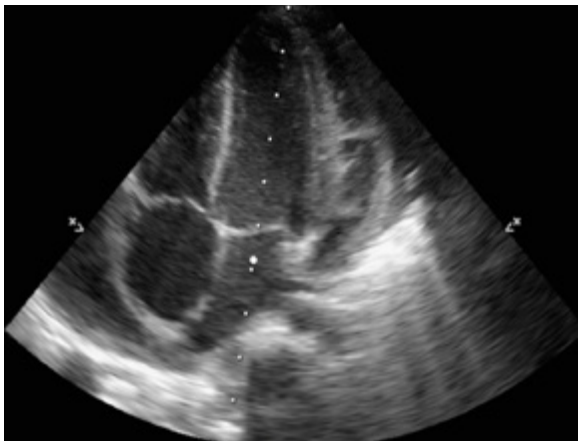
Echocardiogram taken before discharge.
